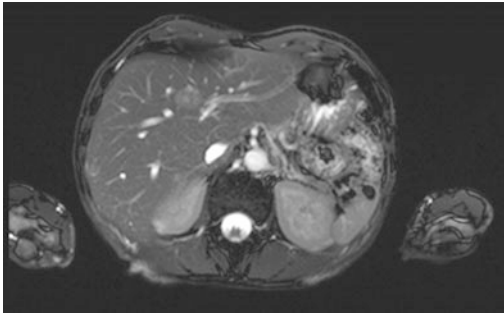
MRI of diffuse liver metastases from MTC demonstrating their hypervascular appearance
